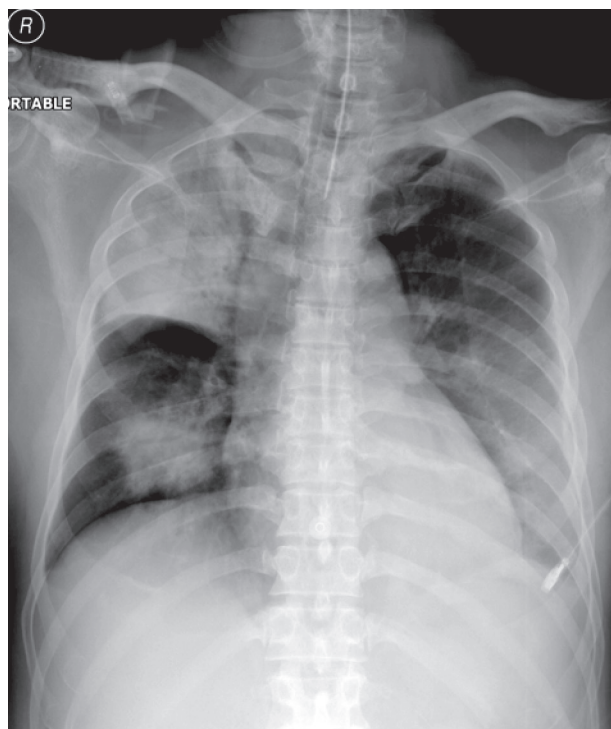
Admission day, chest x-ray showed infiltration at right upper lobe and left lower lobe with dense or mass like lesion infiltration at right lower lobe.
